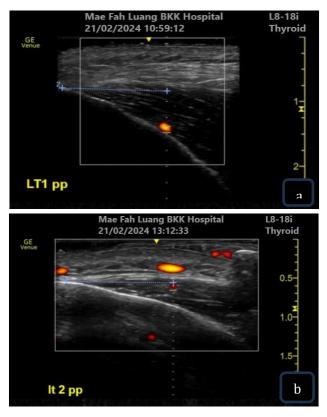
Ultrasound detected the deep temporal artery: (a) above the periosteum and (b) beneath the temporal muscle's deep surface
